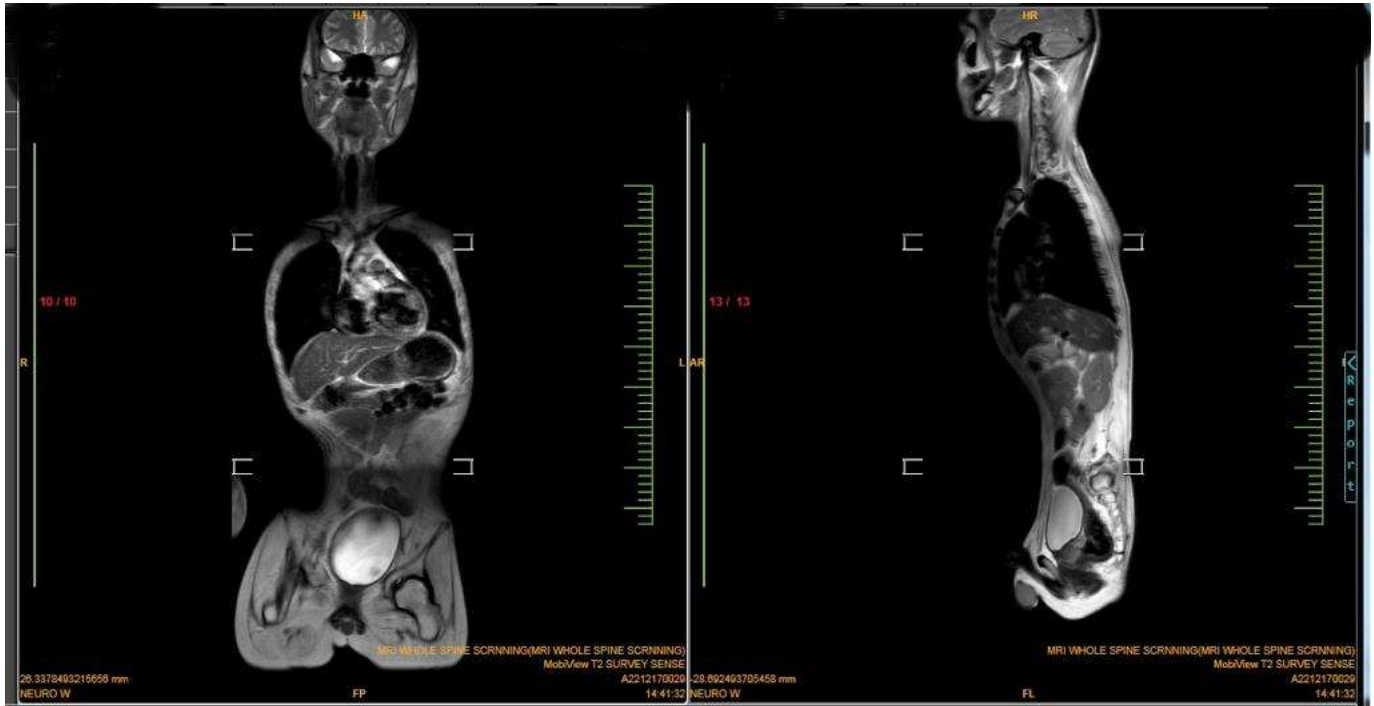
Showing MRI whole spine screening. There was evidence of levoscoliosis noted (Cobb's angle measuring approximately 30 degree). Sign of left side moderate scoliosis.
